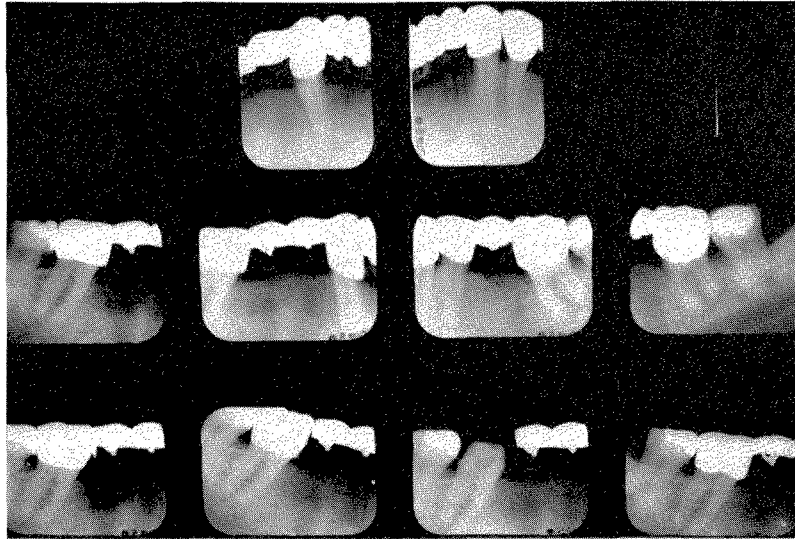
Roentgenograms of the work shown in Figs. 610 to 613. The upper and middle series show the lower splint before the repair. The lower four films show the method of repair from right to left.
